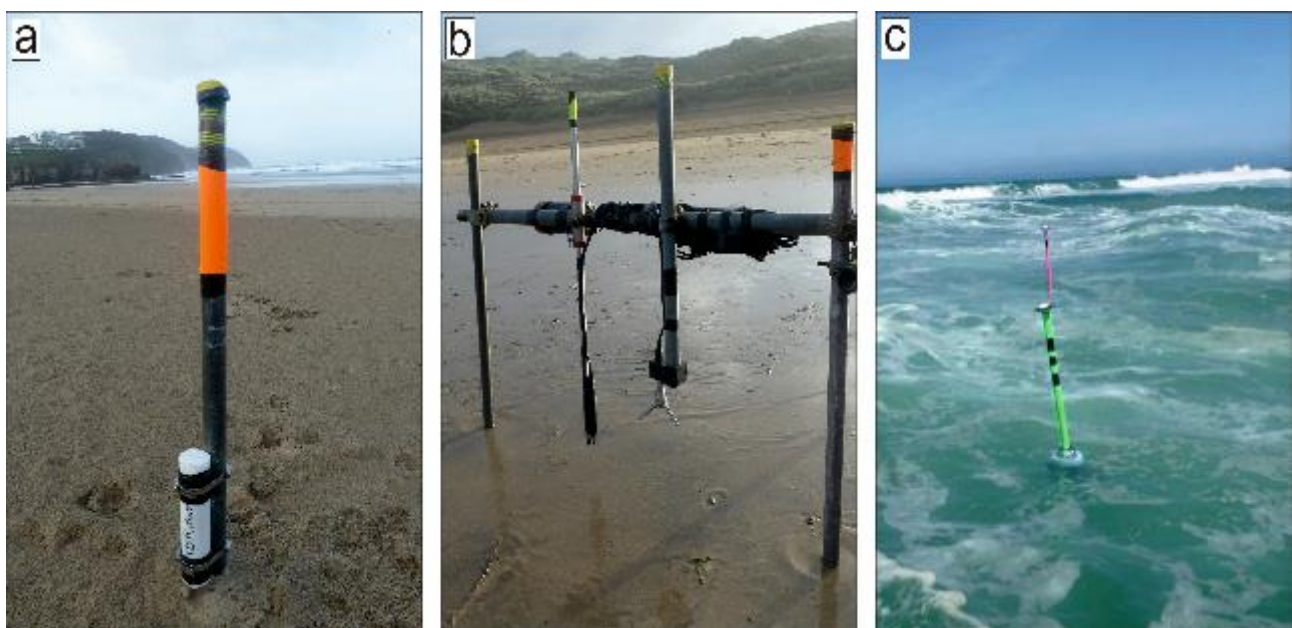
Examples of (a) a bottom-mounted pressure transducer, (b) a PUV rig equipped with an acoustic Doppler velocimeter, and (c) surf zone drifters. (Photos: K. Inch and E. Woodward)
